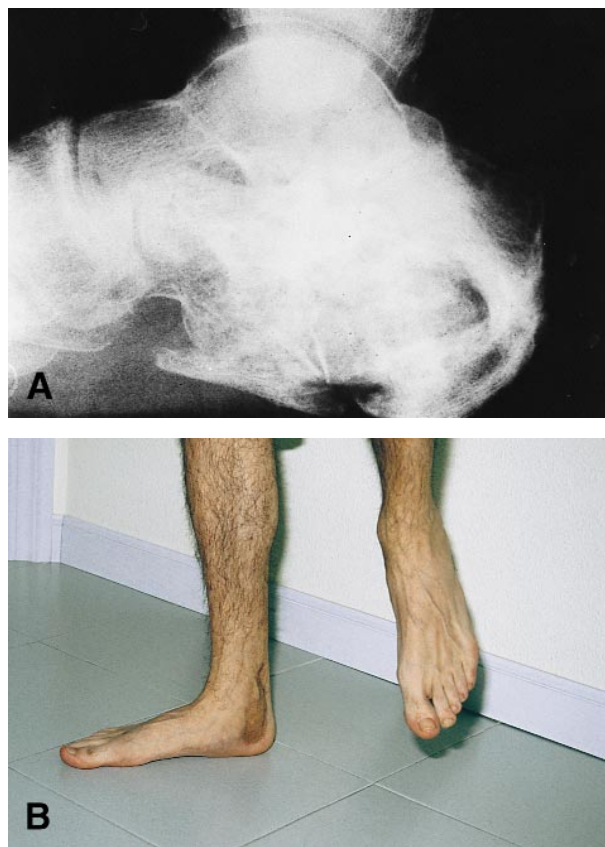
Result at 2½ years. (A) X-ray. (B) Weight-bearing.
